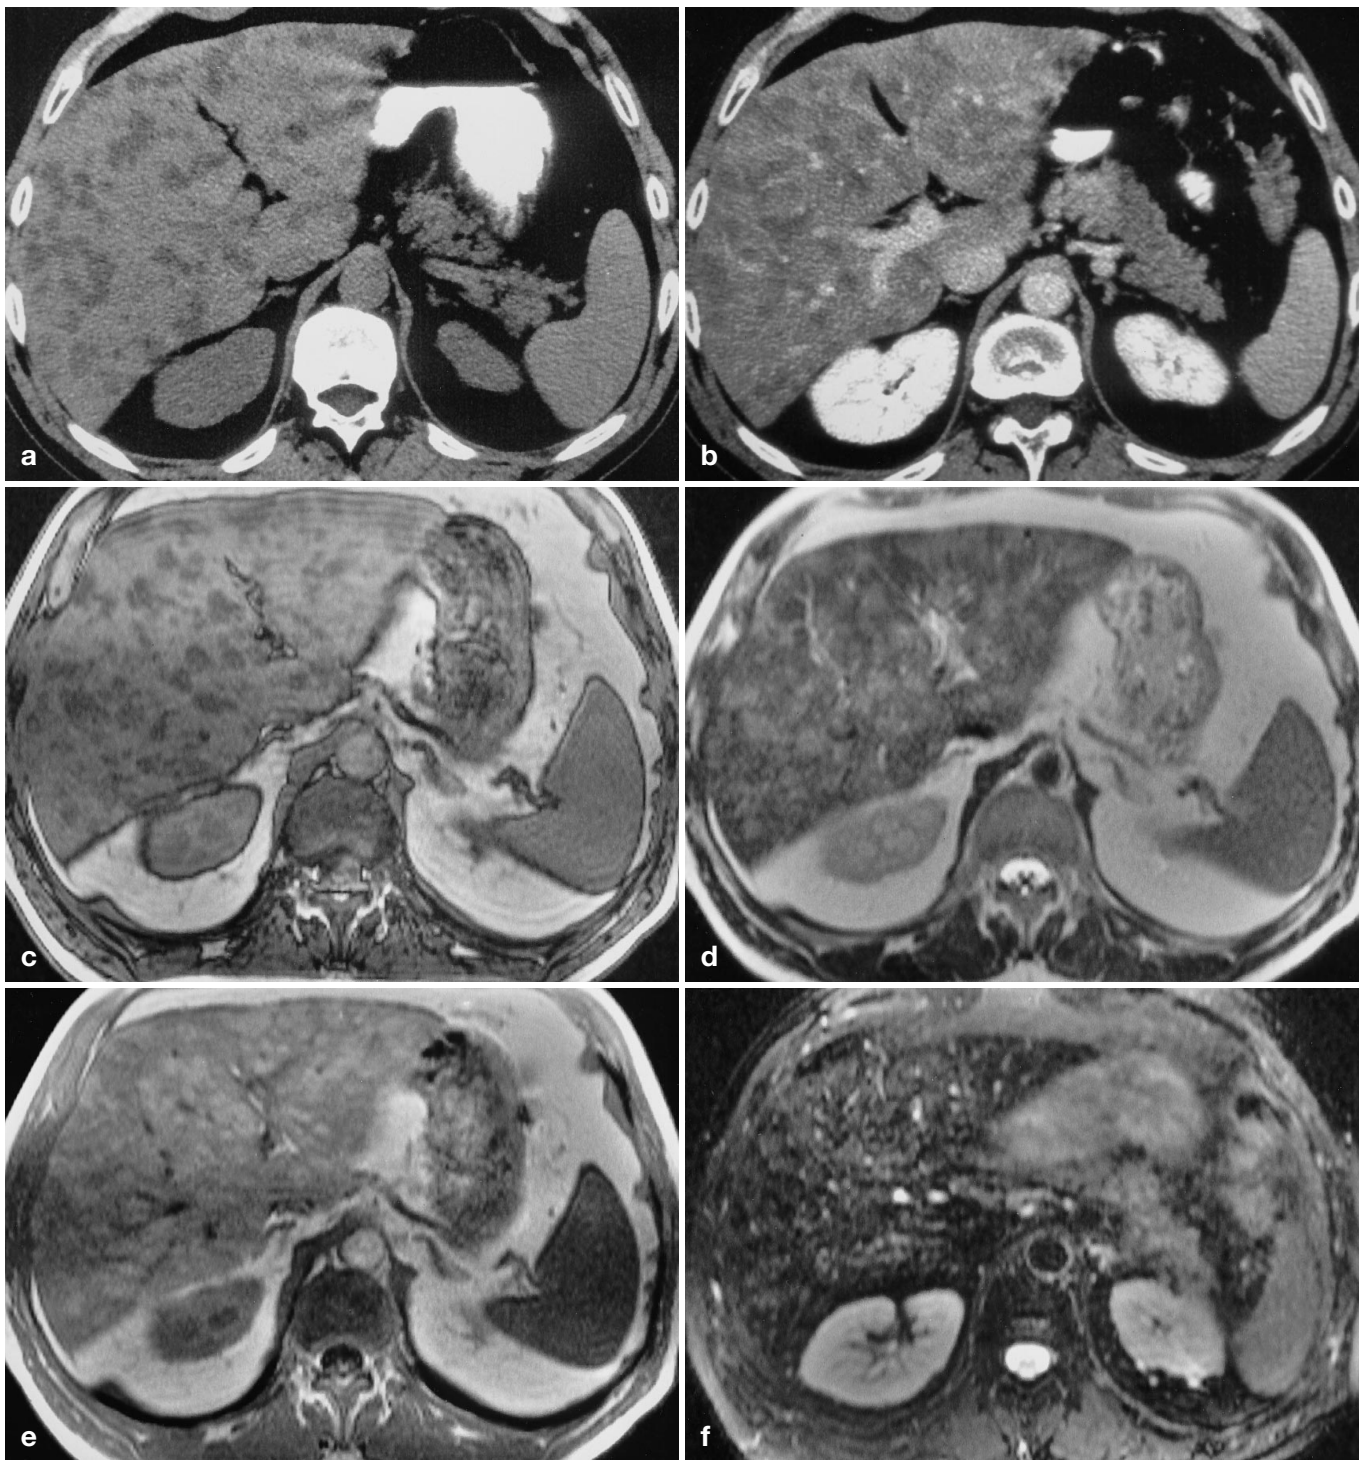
Images of a 53-year-old patient with acquired porphyria tarda due to long-term exposure to hepatotoxic chemicals. On a unenhanced and b contrast material enhanced CT multiple hypodense non-enhancing lesions are present. Based on these findings, multiple metastases were suspected. c On T1-weighted gradient-recalled echo (GRE) opposed-phase and d T2-weighted half-Fourier acquired single-shot turbo spin echo (HASTE) images these lesions appear hypo- and hyperintense, respectively. However, on e T1-weighted GRE in-phase images lesions appear hyperintense, and on f fat-suppressed T2-weighted turbo spin-echo (FSTSE) images lesions are not visible, indicating the presence of multifocal nodular fatty infiltration of the liver (MNFI)
